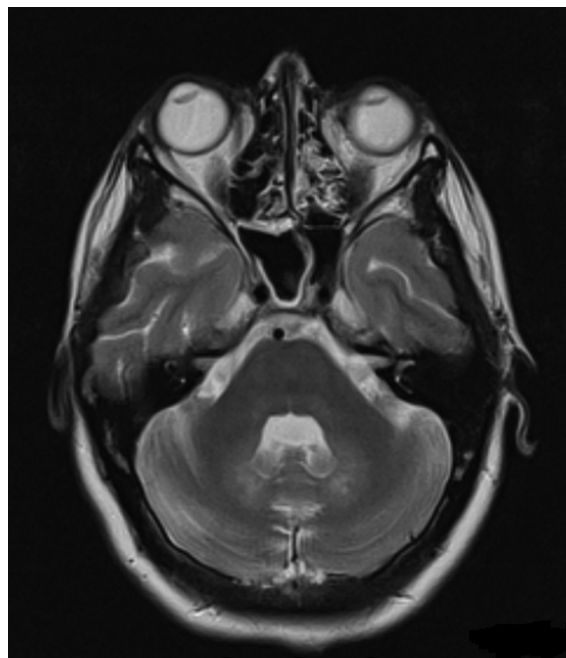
Increased signal in both cerebellar dentate nuclei in T2-weighted examination in cranial magnetic resonance imaging.
